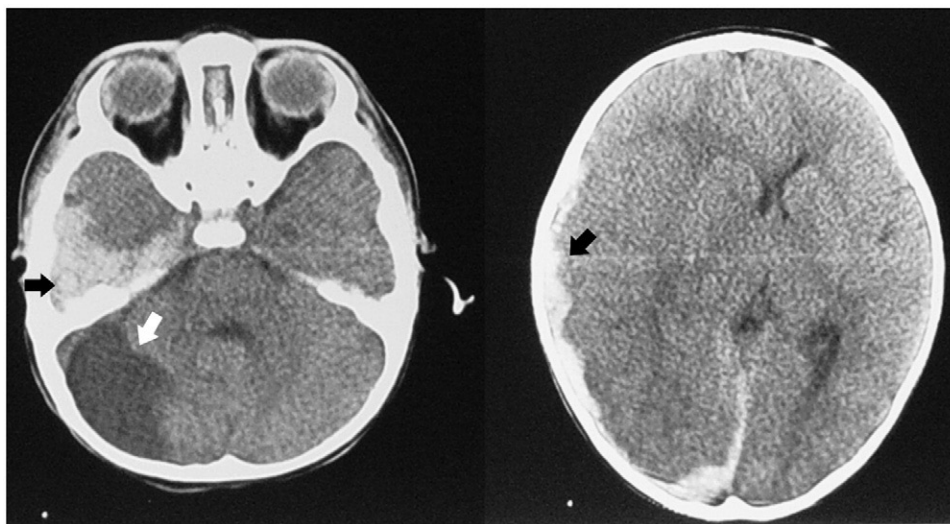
The preoperative CT scans demonstrating an acute subdural hematoma in the right temporoparietooccipital region with midline shift (black arrows) and a coincidental right cerebellar arachnoid cyst (white arrow).
